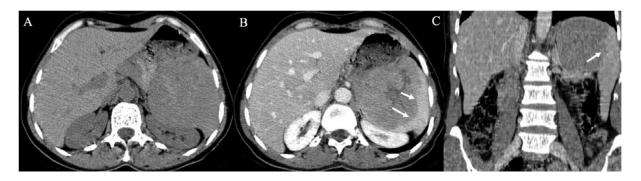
CT Scan images in axial and coronal views before and after injection of contrast agent showing superior polar mass lesion of the spleen, well limited, with heterogeneous enhancement in portal venous phase; the tumor presented a contact with the posterior face of the stomach and the left kidney without sign of invasion.
